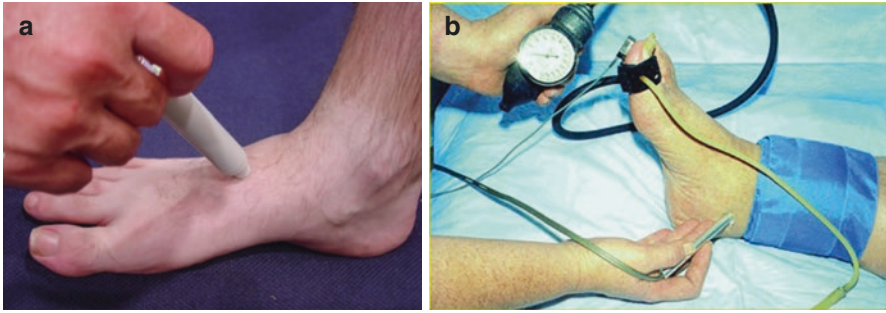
Vascular assessment; (a) Doppler ultrasound for the dorsalis pedis artery; (b) ankle-brachial index/toe-brachial index
